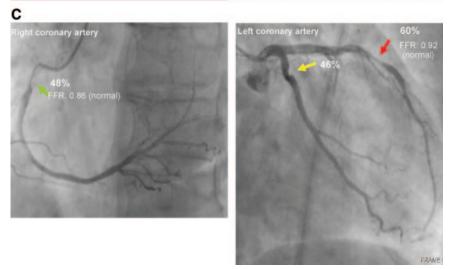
A 69-year-old man with attacks of atypical anginal pain. A, CT showed significant LAD and RCA stenoses with only mild stenosis in the LCx. B, Hybrid images with normal stress PET perfusion (absolute scale, 0 to 3.5 mL ⋅ g⁻¹ ⋅ min⁻¹). Normal perfusion is >2.5 mL ⋅ g⁻¹ ⋅ min⁻¹ (yellow or red). C, ICA with quantitative analysis and FFR. Despite anatomically significant narrowing of the LAD and borderline changes in the RCA, FFR was normal in both vessels, indicating functionally nonsignificant disease.
